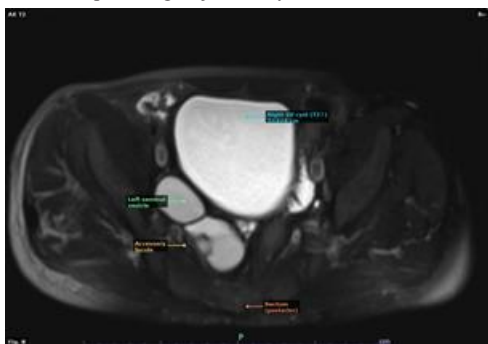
Axial T2 MRI at the level of the seminal vesicles: The right SV cyst (7×3×4 cm, ipsilateral) is strikingly T2-hyperintense. The contralateral left seminal vesicle is identified posteriorly as a smaller grey structure. An accessory locule is visible at the inferior margin of the cyst. The rectum lies posterior.
